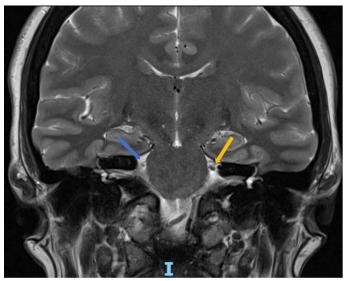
FINDINGS: Coronal T2 MRI of the brain demonstrates atrophy of the right cisternal trigeminal nerve (blue arrow) and a normal left trigeminal nerve (yellow arrow).
